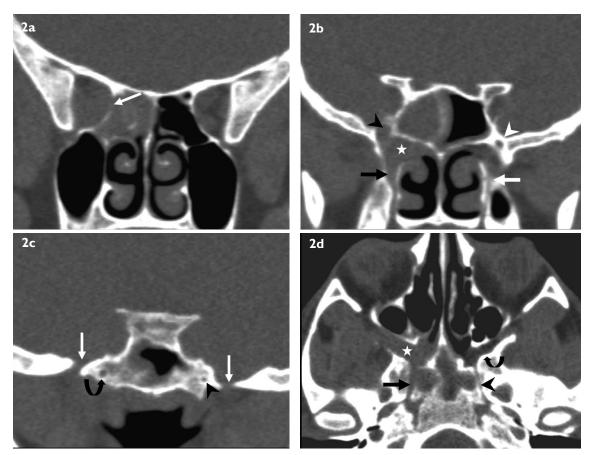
Coronal (a–c, anterior to posterior) and (d) axial CT images taken with bone window setting show erosion of the medial orbital wall (arrow in Fig. 2a), soft tissue causing distension of the pterygopalatine fossa/sphenopalatine foramen (star in Figs. 2b & d), foramen rotundum (black arrowhead in Fig. 2b), proximal portion of the palatine canal (black arrow in Fig. 2b) and the vidian canal (curved black arrow in Fig. 2c and black arrow in Fig. 2d). Normal calibre pterygopalatine fossa (curved black arrow in Fig. 2d), foramen rotundum (white arrowhead in Fig. 2b), palatine canal (white arrow in Fig. 2b) and the vidian canal (arrowhead in Fig. 2c), arrowhead in Fig. 2c), and seen on the left side. The foramen ovale are indicated by white arrows in Fig. 2c.
